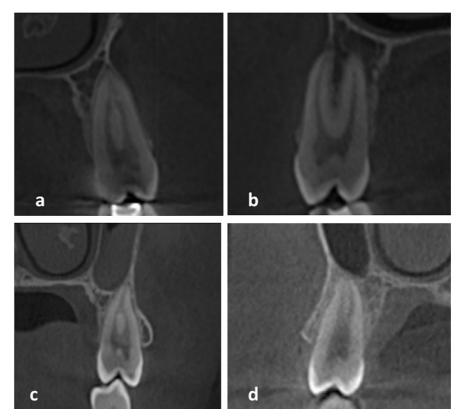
CBCT coronal sections showing different Vertucci types in maxillary premolars; Type II (a), Type IV (b), Type III (c), Type V (d).
